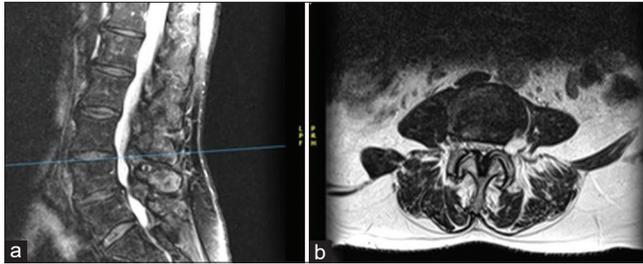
Preoperative magnetic resonance imaging without contrast before first surgery. (a) T2 parasagittal fat suppression. Cystic-appearing lesion in the left L3–4 neural foramen visible on (b) T2 axial at L3–4.
